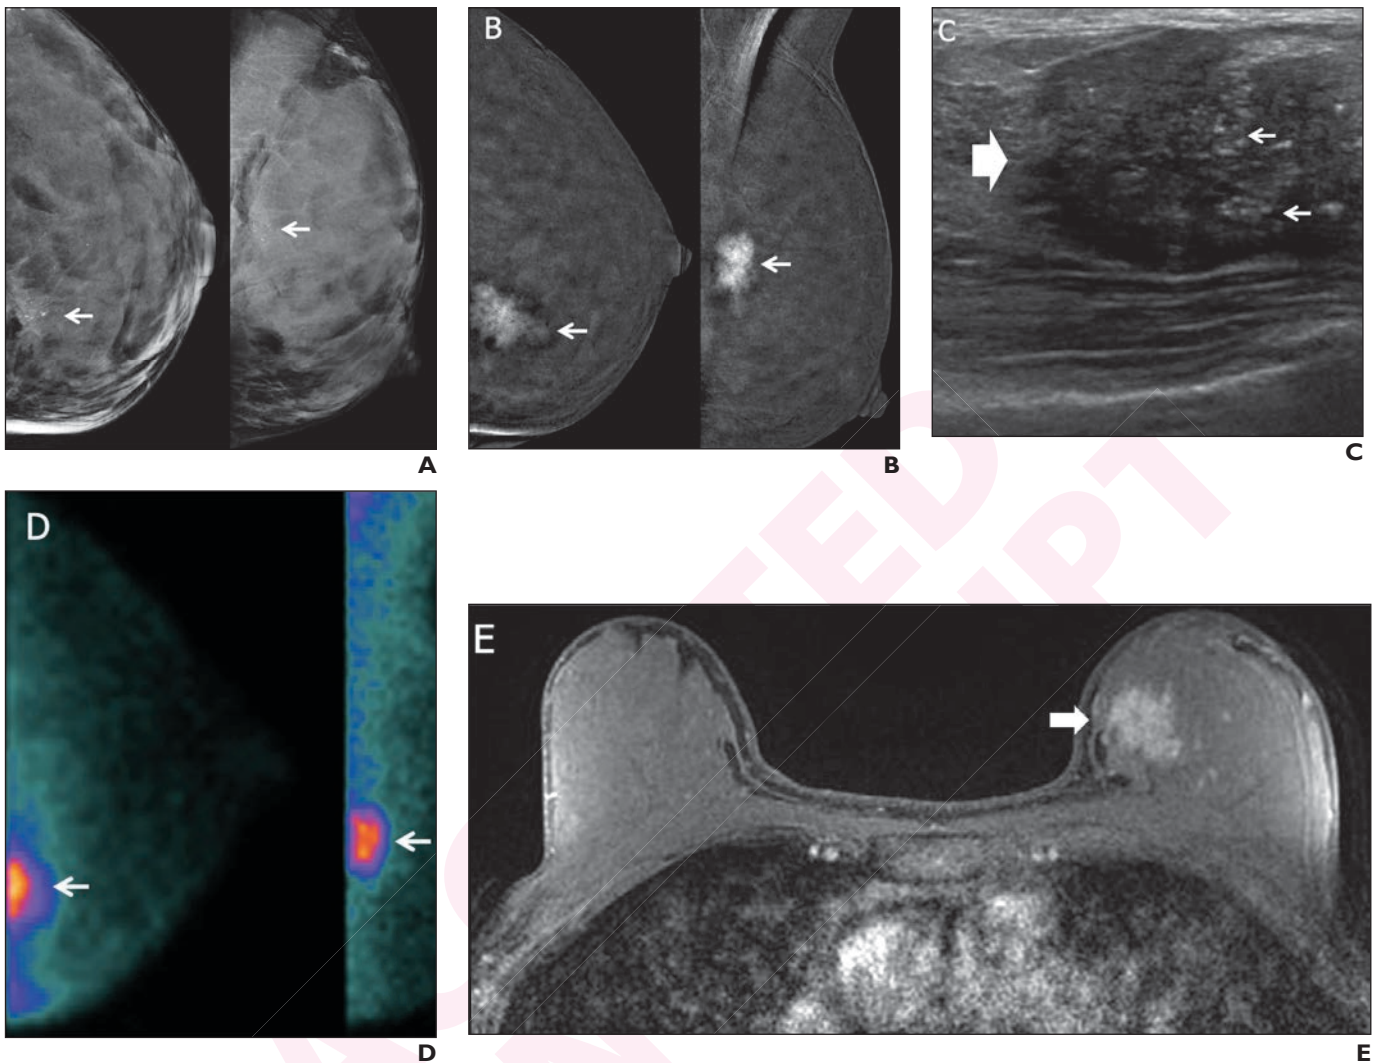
Invasive ductal carcinoma in 51-year-old woman across modalities. A) Screening CC (left) and MLO (right) mammograms of the left breast show regional amorphous and pleomorphic calcifications (arrows) that are well seen despite extremely dense parenchyma. B) Subtraction CC and MLO images from research CEM after i.v. injection of 125 cc Omnipaque 300 show strong enhancement of an irregular 2.7-cm mass (arrows) at the site of calcifications. C) Targeted US shows a partially circumscribed, partially indistinctly marginated slightly hypoechoic 3.1-cm mass (wide arrow) with echogenic calcifications (small arrows). Stereotactic biopsy was performed (to assure optimal sampling of calcifications), showing grade 2 IDC-DCIS, ER/PR/HER2 negative, Ki-67 low at 10%. D) Research CC and MLO molecular breast imaging (10 minute acquisitions following i.v. injection of 7.3 mCi Tc-99m sestamibi) performed after diagnosis shows intense uptake in an irregular 3.4 cm mass (arrows). Note there is slight reduction in inclusion of extreme posterior tissues relative to mammography. E) Axial fat-suppressed T1-weighted MRI shows intense enhancement of irregular 3.0 cm mass at site of known malignancy (arrow). The patient had partial response to primary chemotherapy with two sentinel nodes negative for metastases (or therapy-related changes).
